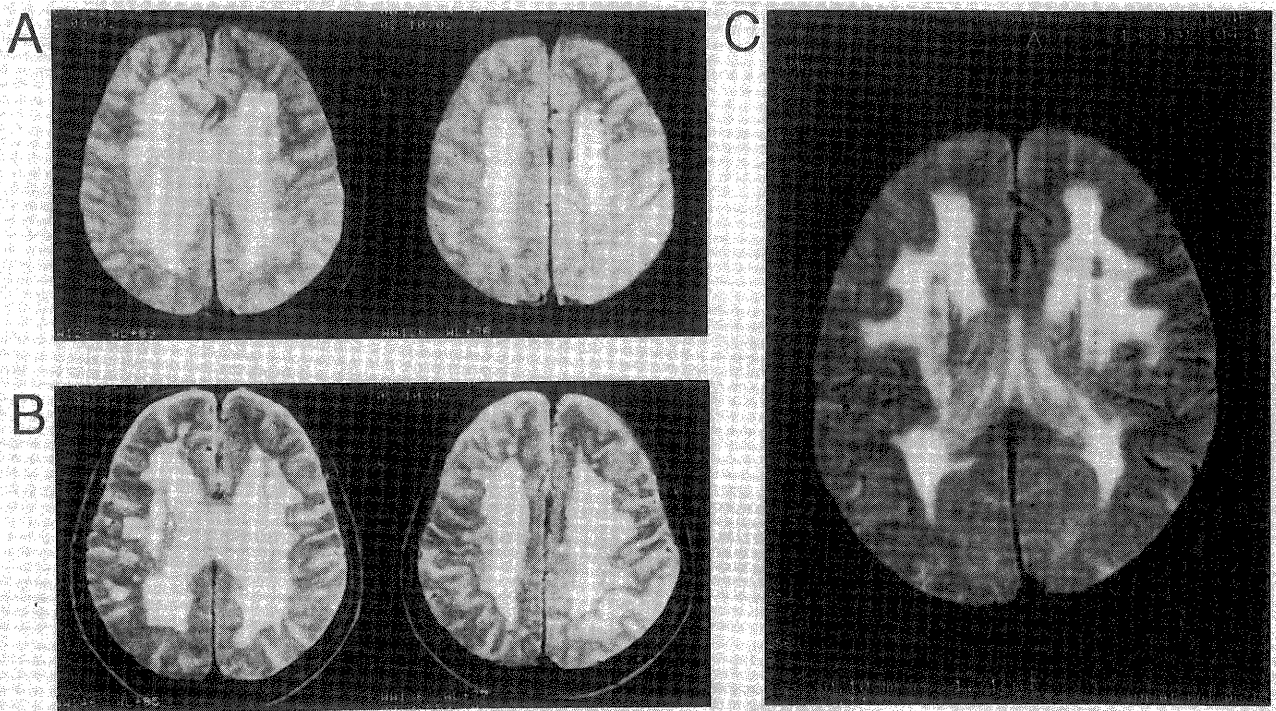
T2-weighted axial magnetic resonance images (spin echo relaxation time 2000, echo delay 100) of the patients demonstrate abnormal high intensity diffusely distributed in the supratentorial white matter. A; patient 1, B; patient 2, and C; patient 3, respectively.
